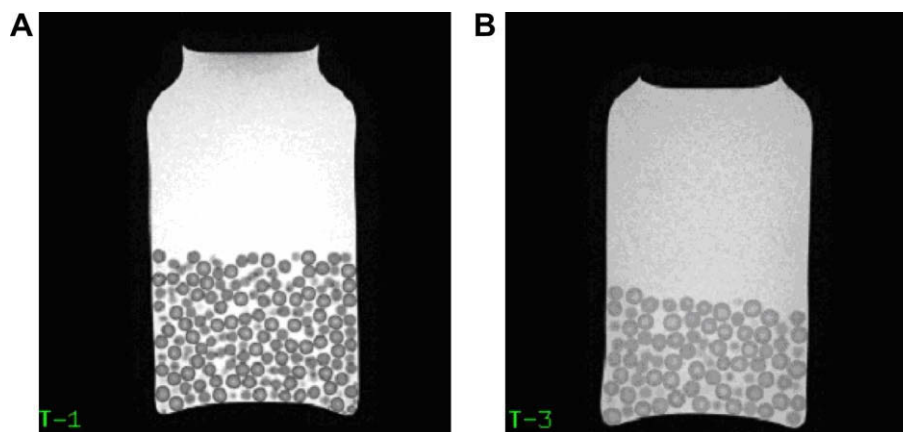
T_2 -weighted high resolution images of (A) strong alginate beads in calcium chloride solution and (B) weak alginate beads in sodium chloride solution. Both images were obtained using a 3.0 T Intera Achieva (Philips Medical Systems) MRI scanner.
